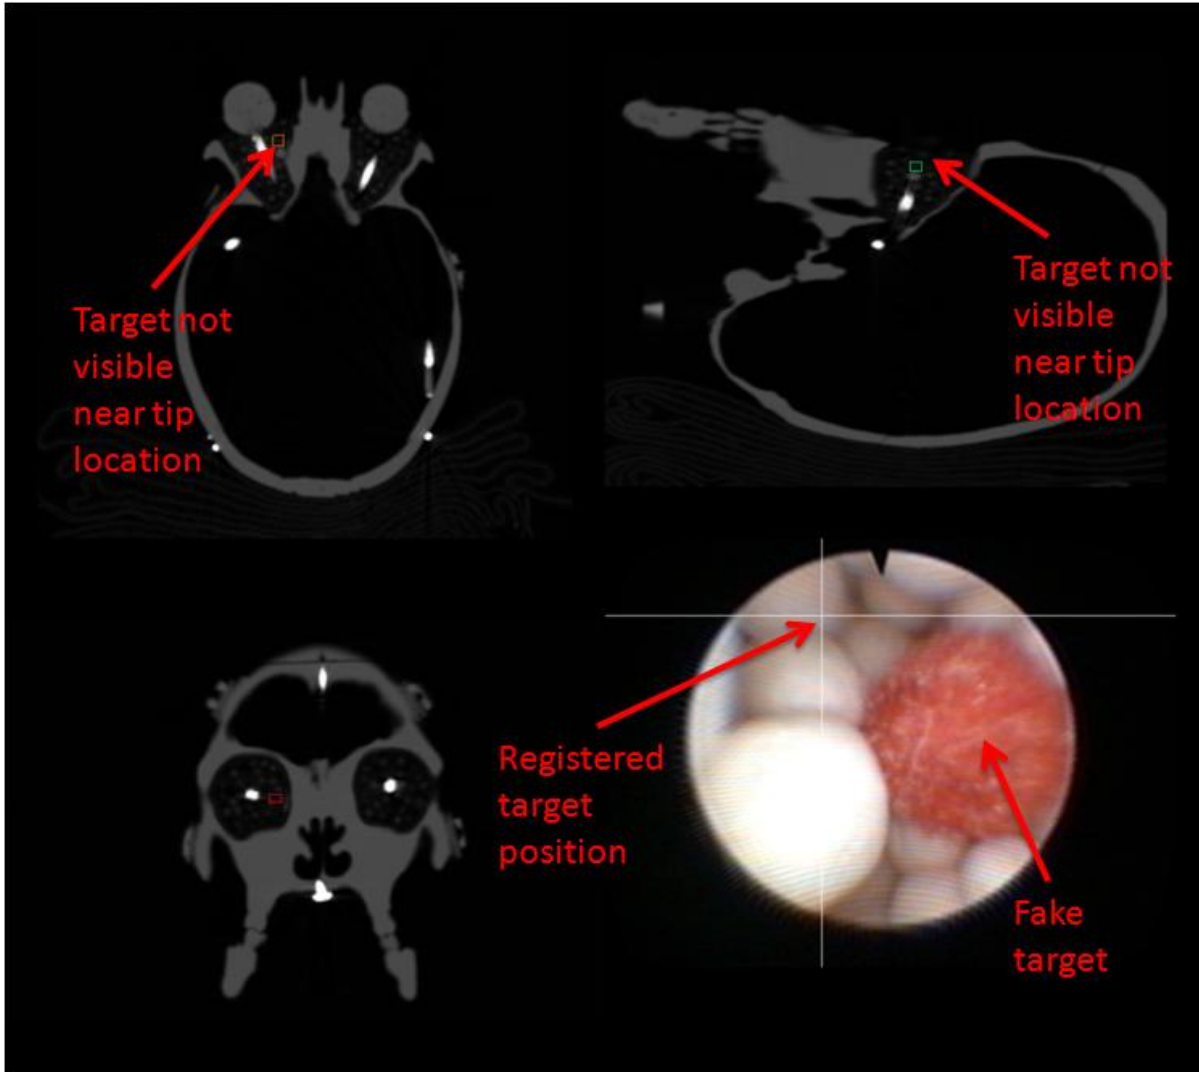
Incorrect target identification with video augmentation. The intersecting lines in the endoscopic video frame indicate that this colored ball is not the target, while there is no radio-opaque object near the registered endoscope tip on the CT images.
